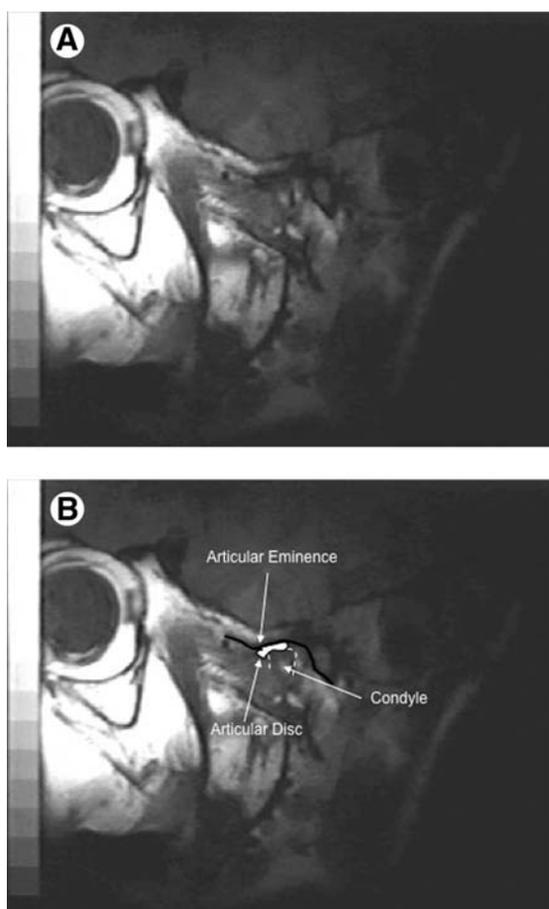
(A) Postoperative MRI image of the second patient showing improved anatomy and relationship of the temporal bone, articular disk and condyle, resembling a normal joint. (B) Outline and labels for A.
